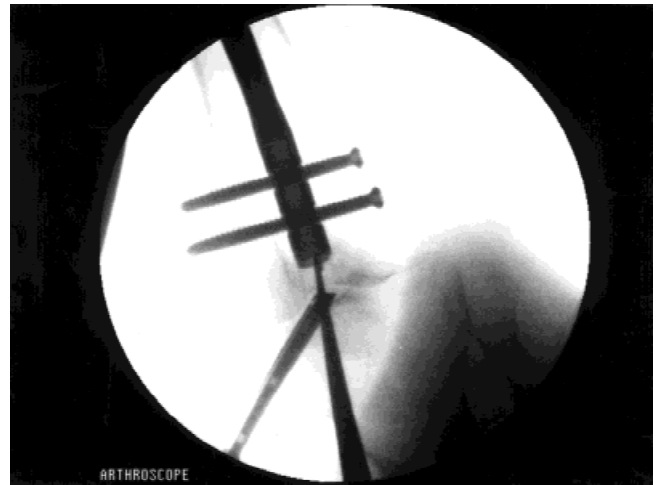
(A) Intraoperative lateral and (B) AP fluoroscopic x-ray localizing the nail in two planes. A curette may be used to push through any overlying fibrous tissue covering the nail.
